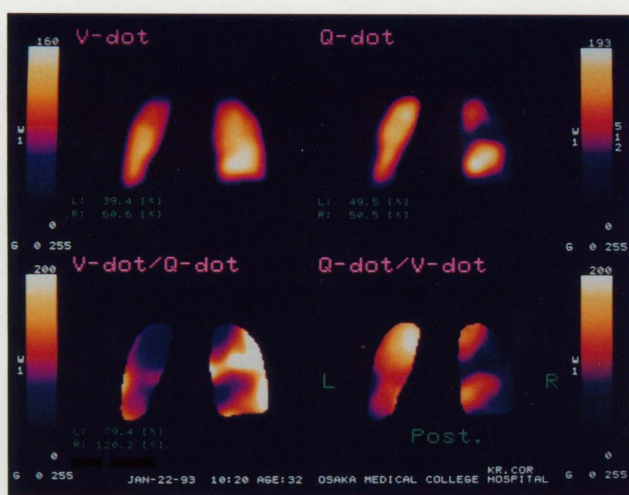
A posterior coronal SPECT superimposed image shows a high  $\dot{V}/\dot{Q}$  area matched with the perfusion defect.
